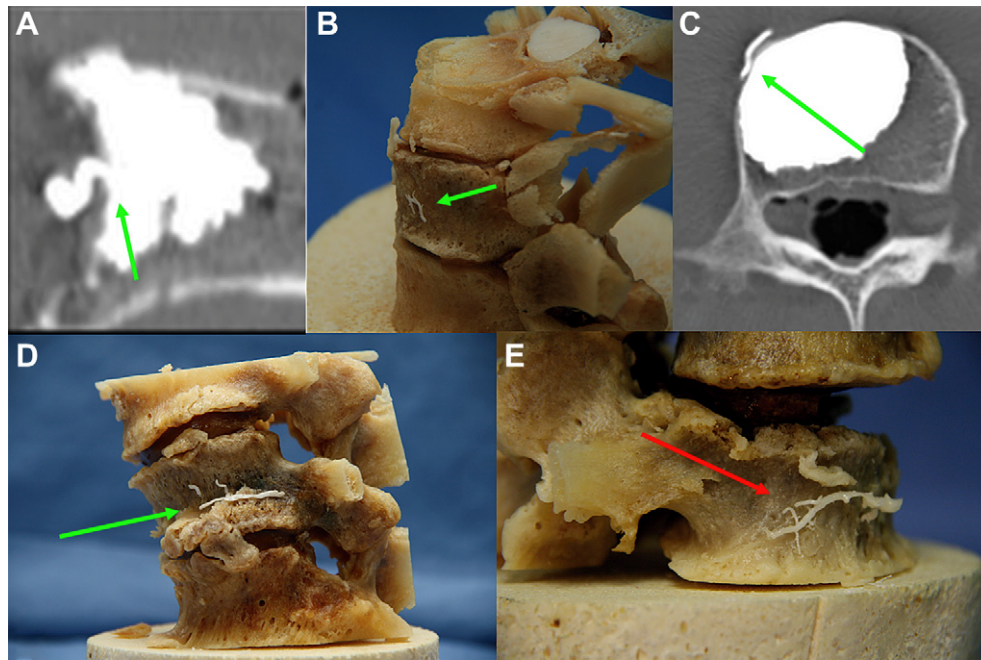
Computed tomography and still images of cement leakage into the surrounding vessels (green arrows). Note the smaller vessels conjoining the larger vessel filled with extravasated cement (red arrow).
